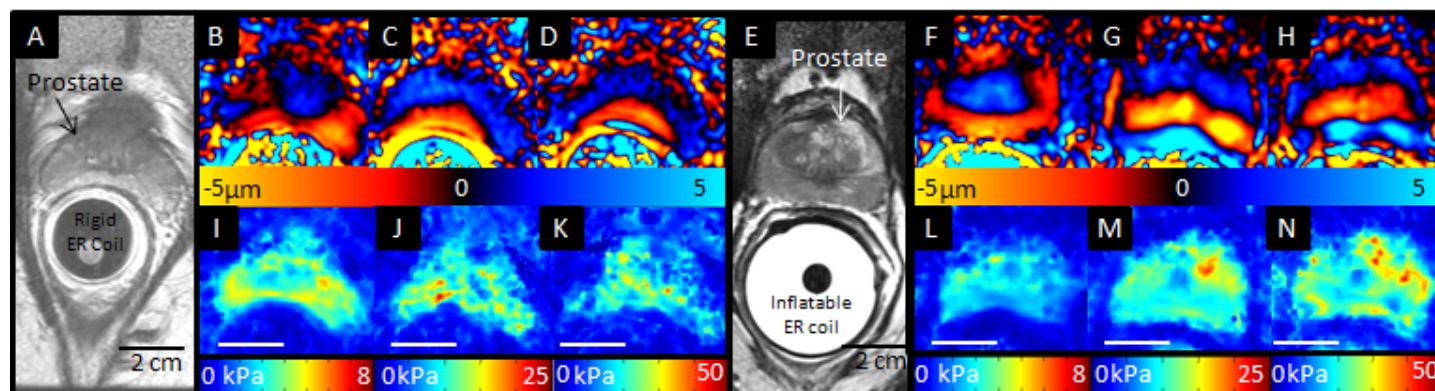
A) and E) Axial pelvic T2-weighted image of volunteers 7 and 9 with inserted rigid and inflatable endorectal coils, respectively. B-D) and F-H) Wave images obtained from SI motion encoding for volunteers 7 and 9 at 100Hz, 200Hz, and 300Hz, respectively. I-K) and L-N) Respective elastograms for each volunteer with motion encoding in all three directions.
